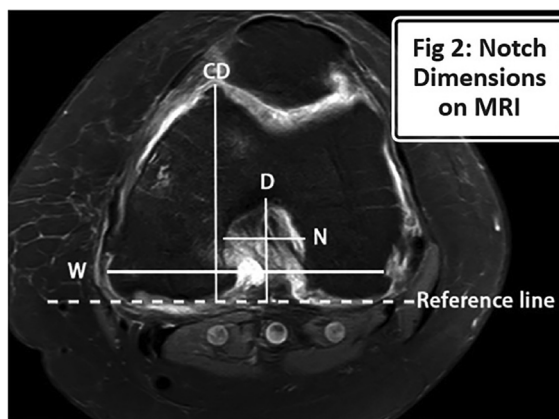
Method of determining parameters of the intercondylar notch on axial MRI scan. N: notch width; W: femoral condyle width; D: notch depth; CD: lateral femoral condyle depth; White dotted line: reference line. Notch width index (NWI) = N/W ; Notch depth index (NDI) = D/CD [17].
